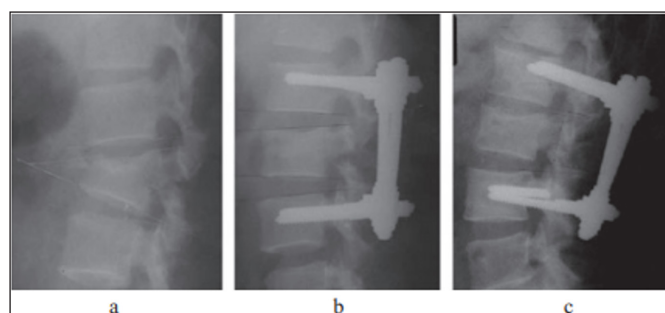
For a 47-year-old male with L2 burst fracture, APF was used for his treatment), (a) pre-operative radiograph, (b) post-surgery radiograph, (c) radiograph after 6 years of operation, showing broken pedicle screw and upper disc degeneration
